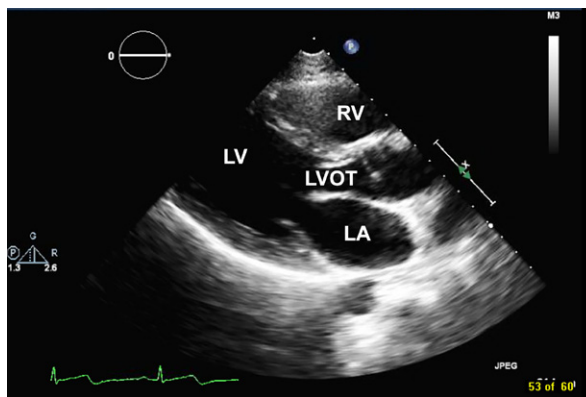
Transthoracic echocardiogram (parasternal long-axis view) one month after excision shows no mass.
